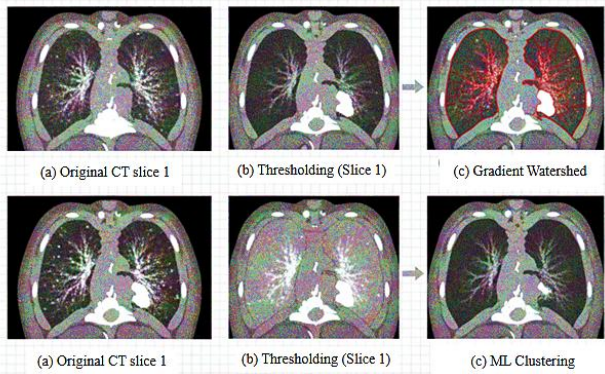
Classical segmentation on lung CT: thresholding, ML, gradient watershed.
